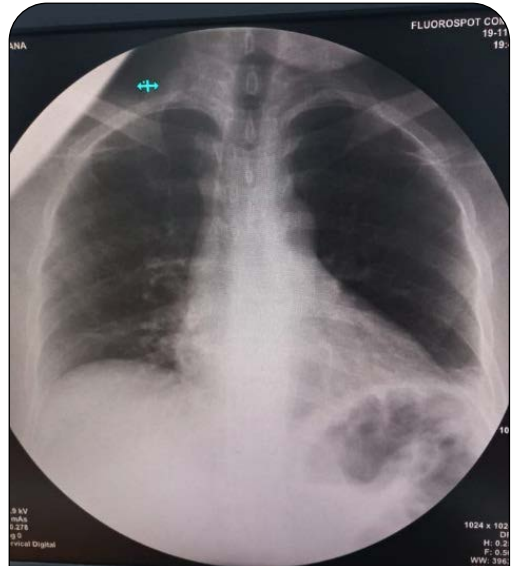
Posteroanterior thoracic X-ray with the heart on its normal location (levocardia).
